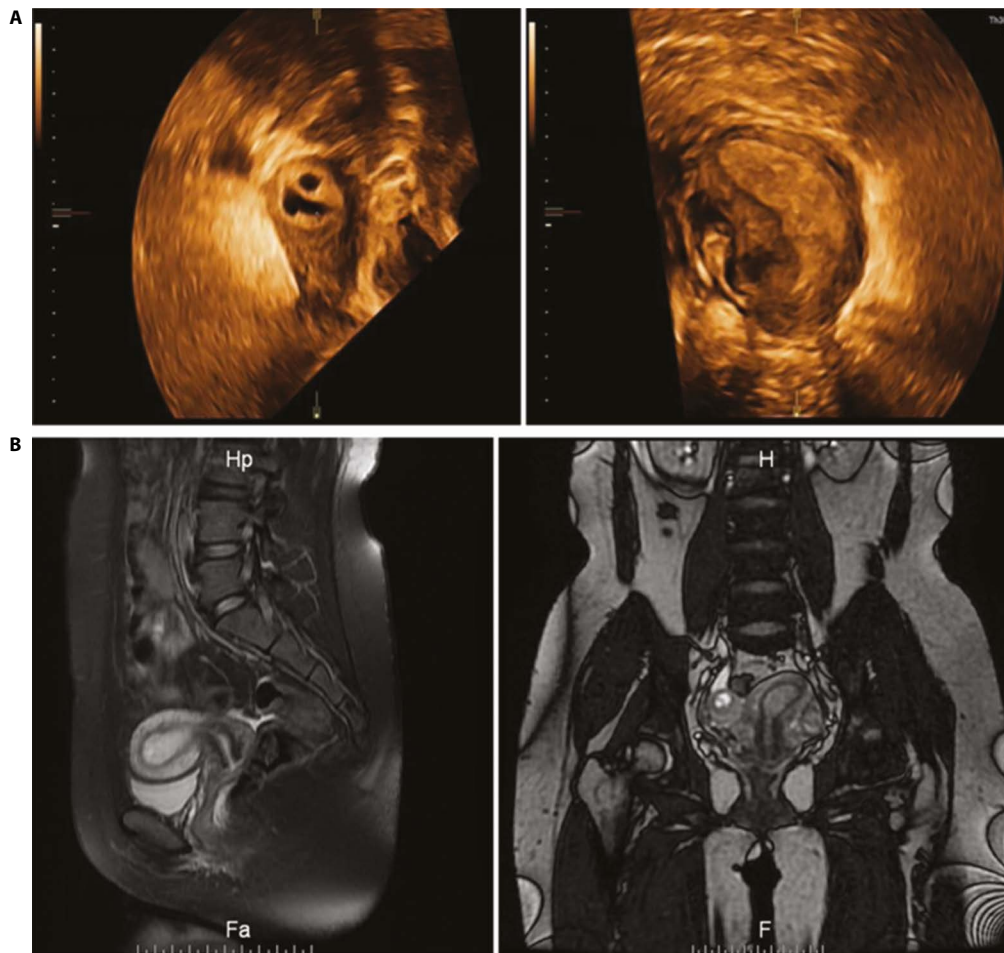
Three-dimensional ultrasound (A) and pelvic magnetic resonance imaging (B) showed the rudimentary horn pregnancy
